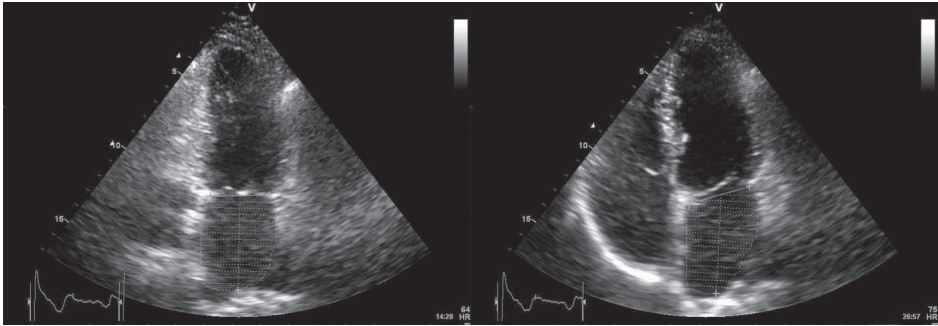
Measurement of LA volumes with transthoracic echocardiography using the modified biplane Simpson's rule. The maximum LA volume is assessed during ventricular systole in the apical 2-chamber (left panel) and apical 4-chamber (right panel) views. Maximal LA volume was 46 ml, minimal LA volume was 22 ml, resulting in an LA ejection fraction of 53%.
